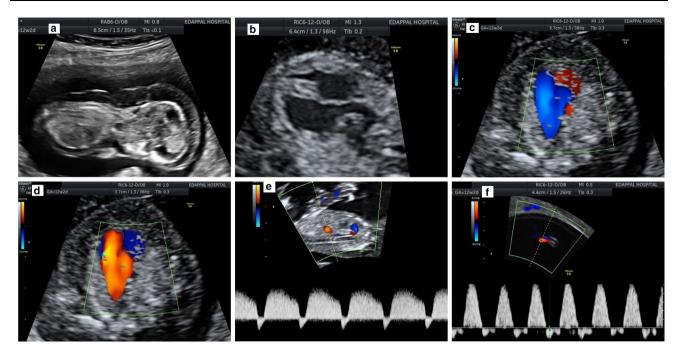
First trimester ultrasound features of absent pulmonary and aortic valve. a Fetus at 12^{+2} weeks with edema all around the fetus (hydrops), b the left ventricular outflow view depicting septo-aortic continuity and ruling out TOF, c the 3VT view showing antegrade flow in both arches during systole, d retrograde flow in both arches
